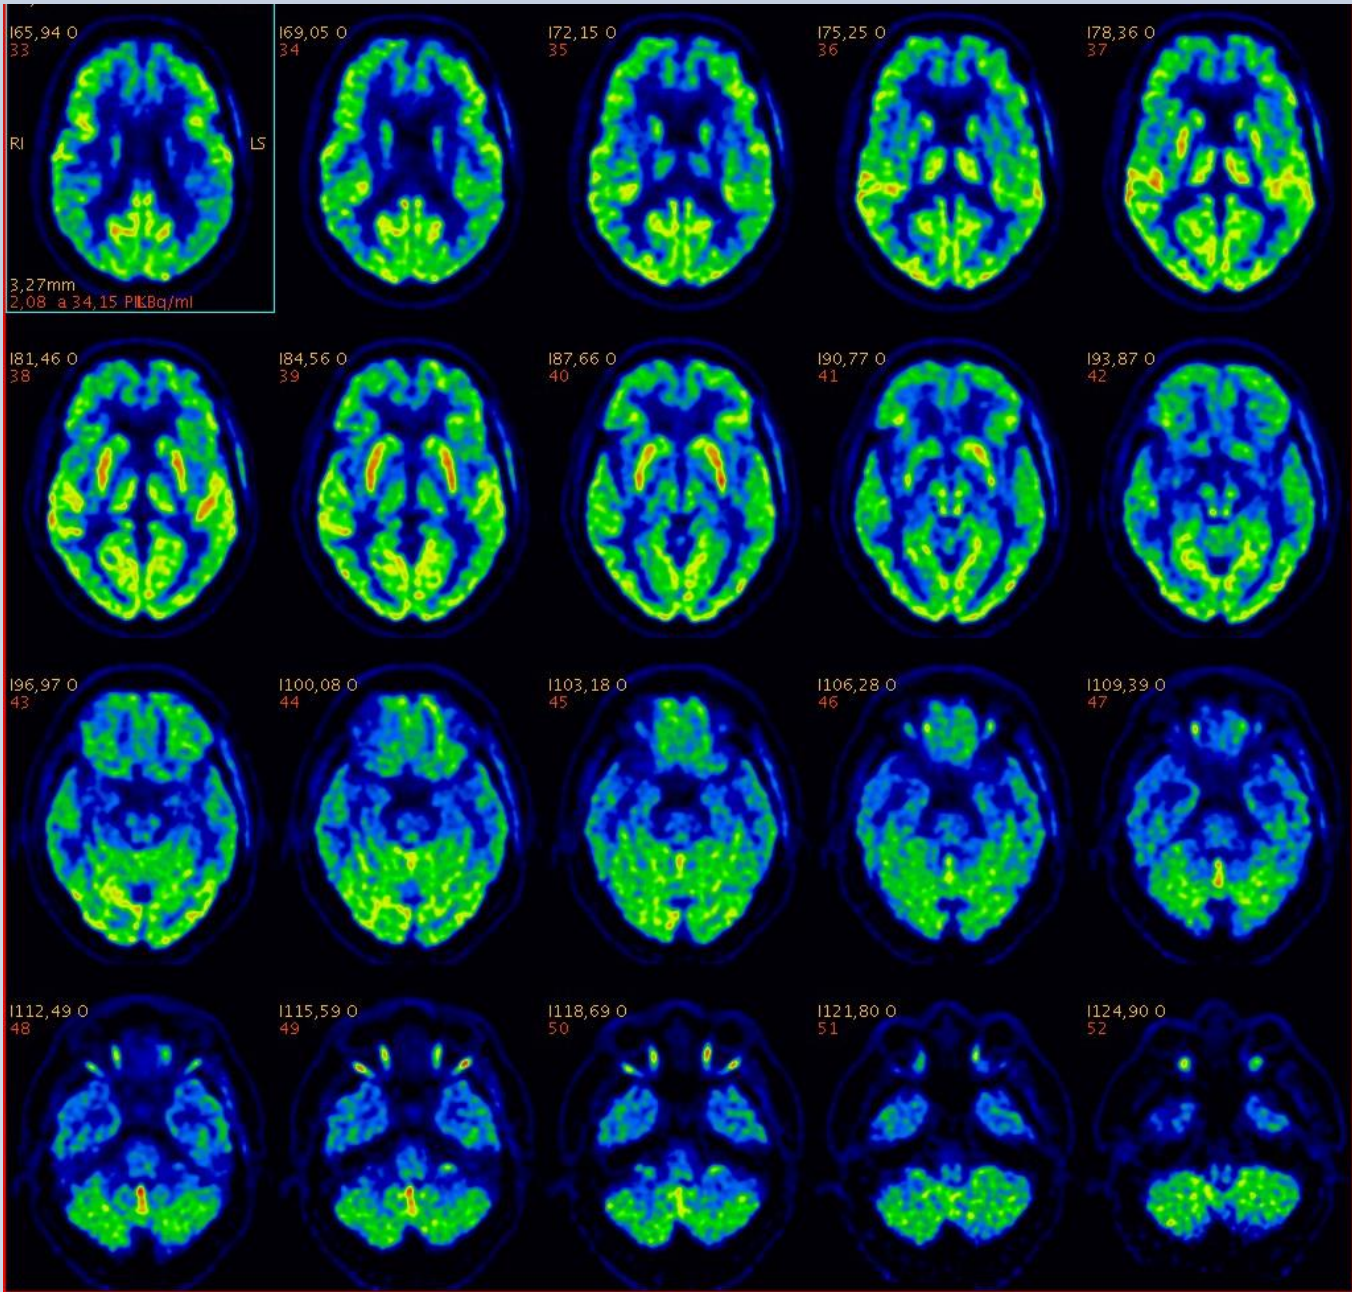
FDG-PET of 69 years old man with 30 CAG repeats.
